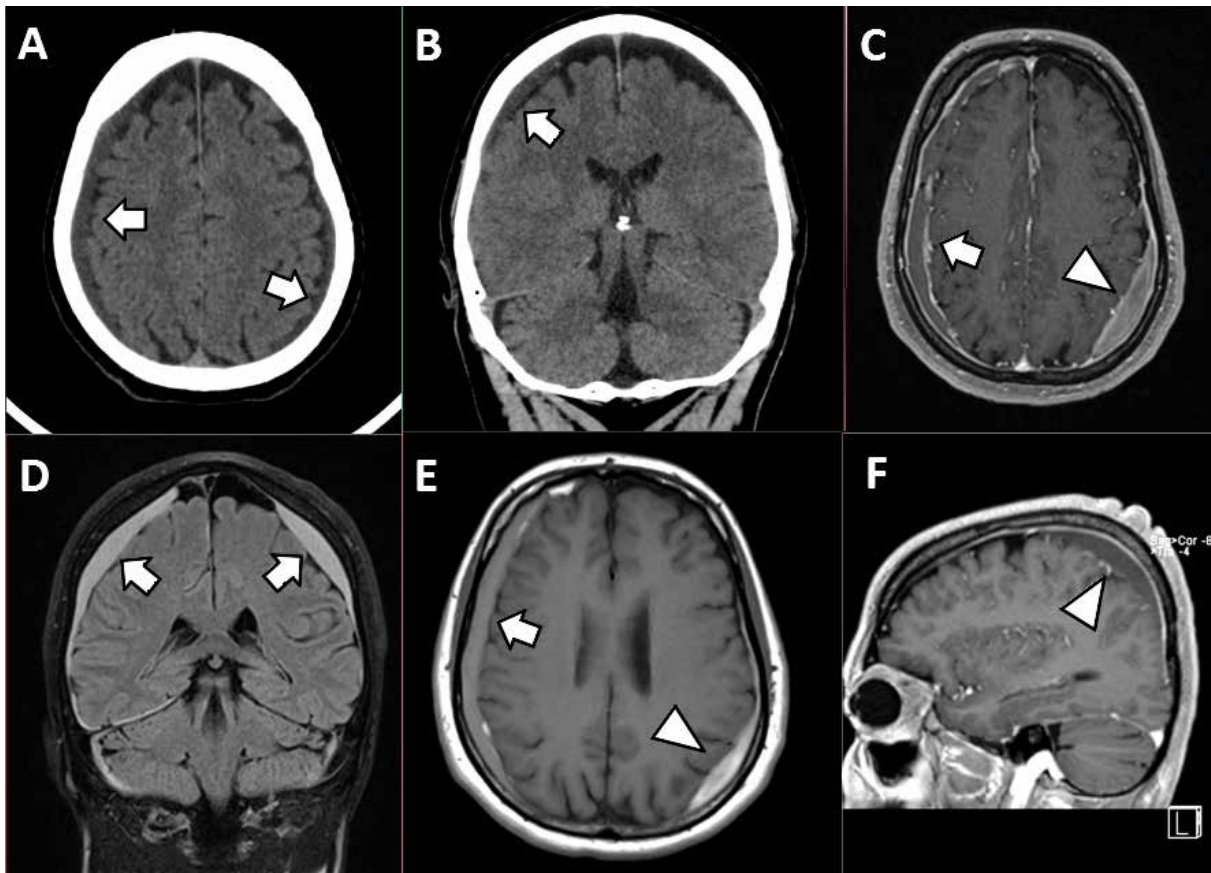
A, B) CT scan at admission and C, D) MRI FLAIR images show bilateral meningeal thickening with fluid subdural collection (arrows). E, F) MRI T1 before and after contrast administration show subdural hematoma with hyperdense hematic component (arrowheads) and bilateral meningeal thickening with contrast enhancement.
